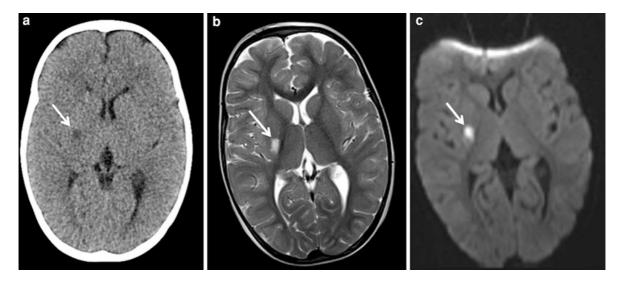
A 3-year-old boy with acute neurologic deficit with *right-sided* paresis. a Axial 5 mm CT at 120 kV and 108 mAs shows *oval* low density region in *right* capsulo-lenticular region (*arrow*). The CTDI vol of exam was 17 mGy and DLP 312 mGy.cm, which
